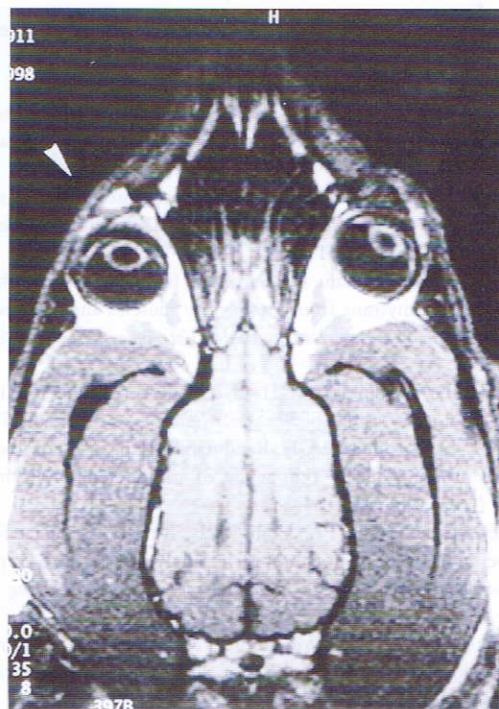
Magnetic resonance imaging of a 4-year-old Irish Wolfhound with right ventromedial strabismus (case 1). T1-weighted image, dorsal orientation. Note the deviation of the right globe (arrow).
